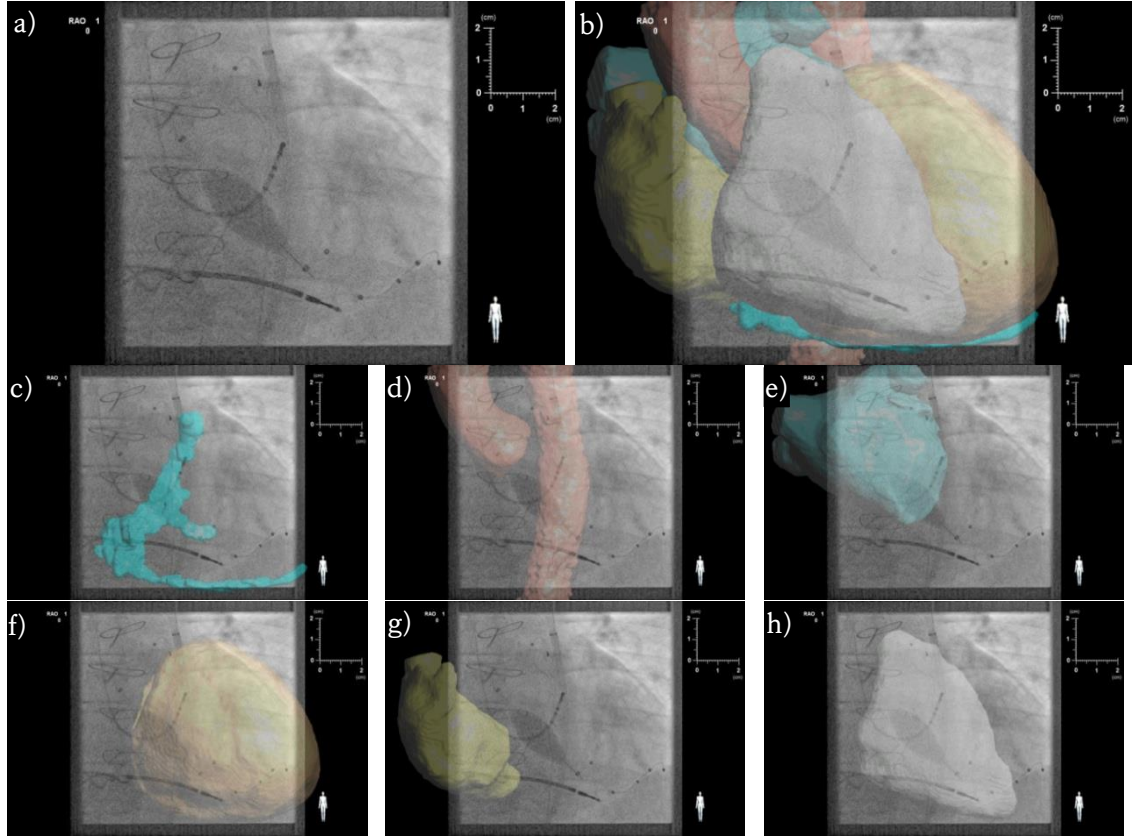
a) PA X-ray view of the patient's heart and catheters inserted inside it. Once 2D-3D registration is performed, surface renderings of segmented regions are overlaid onto the X-ray view. b) Overlay showing all regions, which include the c) CS, d) Ao, e) LA, f) LV myocardium, g) RA and h) RV blood pool. All eight images were used by clinical experts to assess the accuracy of the registration of each cardiac chamber and of the whole heart.
